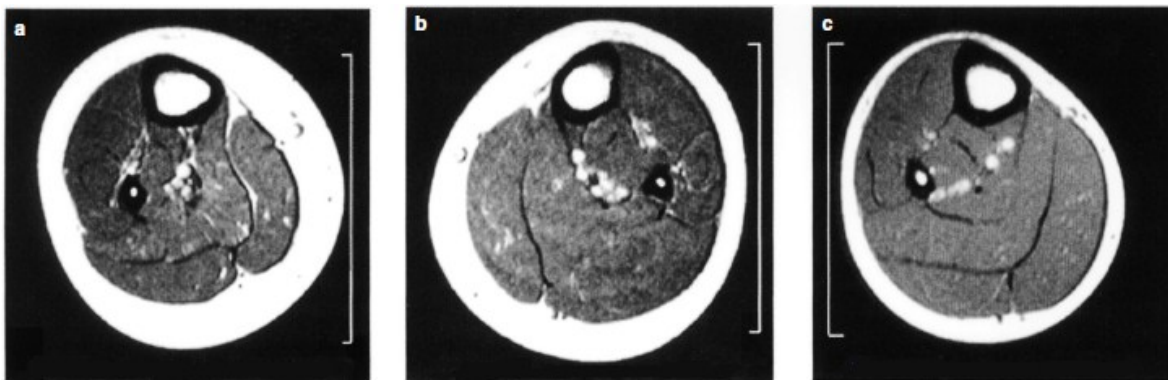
MRI scans from the lower limbs of a child with hemiplegia (a) paretic leg, (b) non-paretic leg, and (c) leg of an age-matched child without neurological impairment. Calibration bars are 8 cm (Elder et al. 2003).
